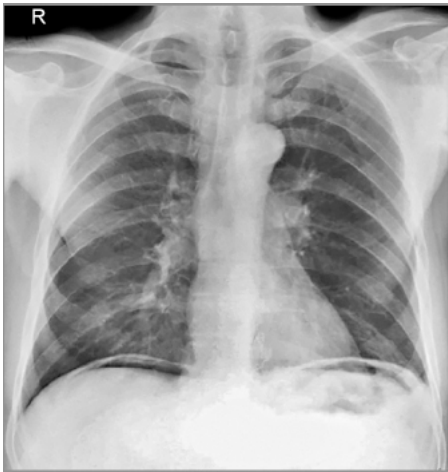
Chest X-ray PA view showing cardiomegaly with features of mitral valve disease—splaying of carina, double atrial shadow, straightening of left heart border, mitral valve metallic prosthesis, enlarged left atrial appendage, prominent pulmonary artery, prominent upper lobe veins (stag's antler sign).
